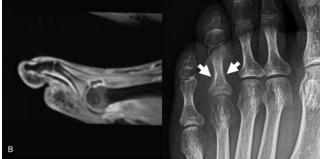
Sagittal contrast-enhanced T1w fat-saturated MRI of the forefoot and the corresponding radiographs in 2 patients. (A) MRI of a 66-year-old female patient admitted with foot pain and suspicion of arthritis showing a subchondral fracture of the second metatarsal head. Both the radiograph and the MRI demonstrate minor linear subchondral sclerosis and lost sphericity of articular surface due to an infraction (black arrows). (B) MRI of a 51-year-old male patient with long standing axSpA with peripheral involvement showing dactylitis of the fourth toe with dominant arthritis of the metatarsophalangeal joint, no fracture. The radiograph shows a mineralized periostal reaction of the proximal basophalangeal metadiaphysis (white arrows), no fracture. AxSpA: axial spondyloarthritis; MRI: magnetic resonance imaging; T1w: T1-weighted.
